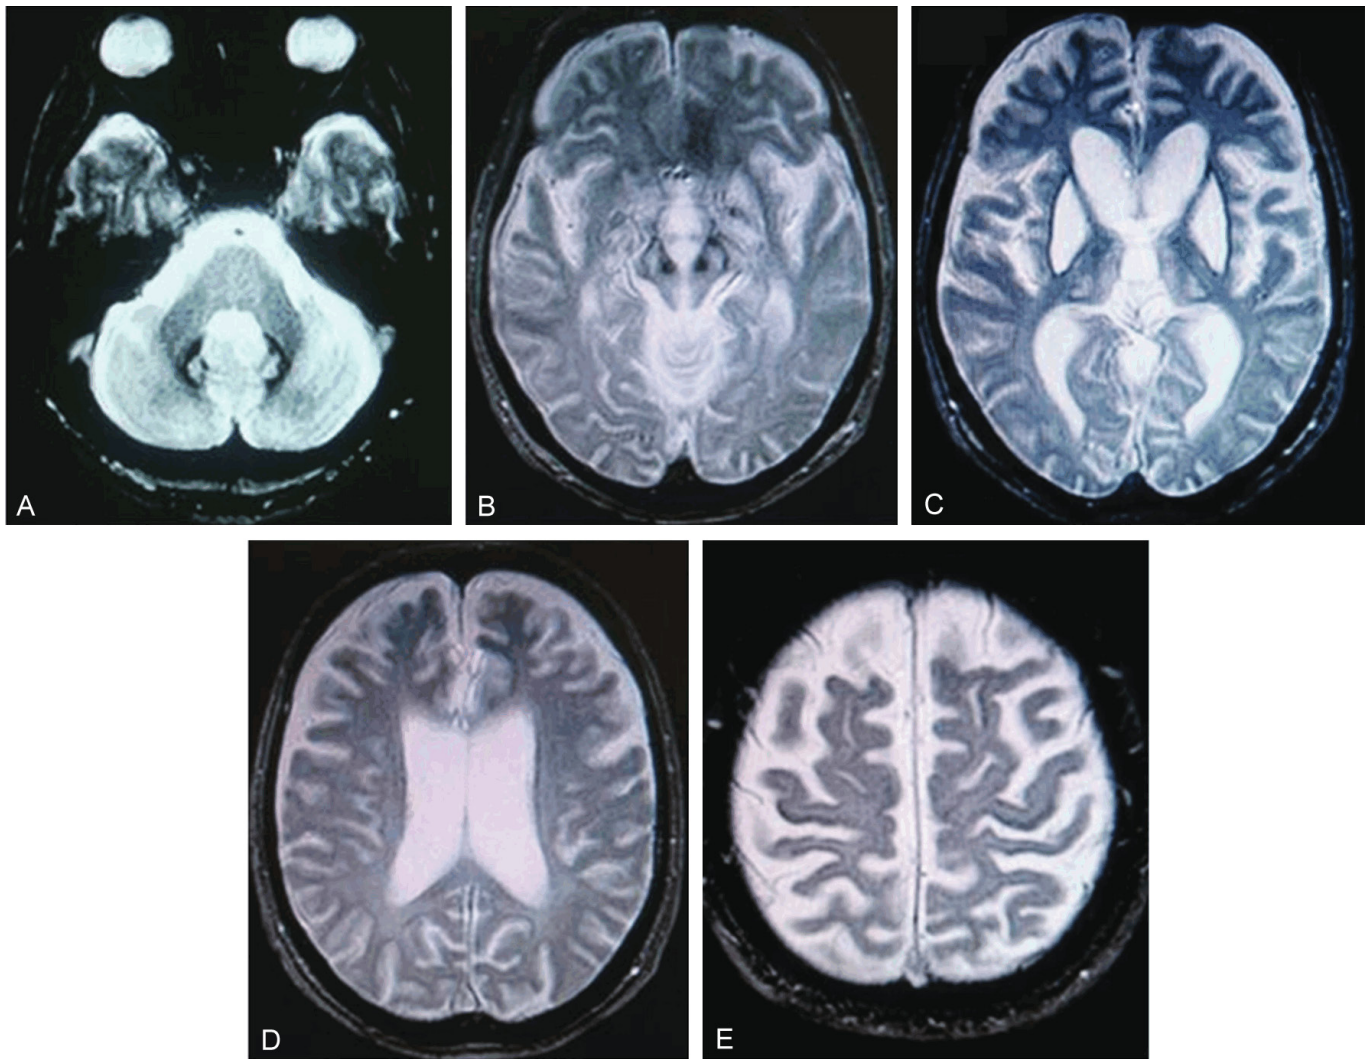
T2-weighted gradient echo sequence images (TR 400 ms/TE 25 ms) of a 42-year-old patient reveal specific abnormalities. A. The pontine level cross-section shows more pronounced signal loss with central hyperintense lesions in the dentate nucleus, more evident than in T2-weighted imaging (T2WI). B. The midbrain section highlights distinct hypointense changes in the red nucleus. C. The basal ganglia exhibit cystic degeneration characterized by a peripheral rim of signal loss, along with bilateral hyperintense abnormalities surrounded by mild hypointensity in the thalamus. D. A section through the central lateral ventricles is depicted. E. The cerebral cortex demonstrates evidence of iron deposition, which is observed as signal loss. Reproduced from MRI findings in neuroferritinopathy. *Neurology research international*. 2012;2012(1):197438. © 2012, with permission under Creative Commons Attribution 4.0 International Public License (<https://creativecommons.org/licenses/by/4.0/legalcode>) [6].
